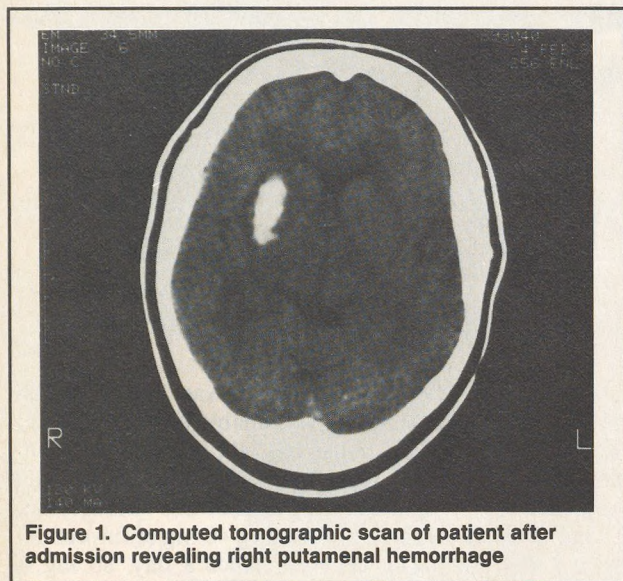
Computed tomographic scan of patient after admission revealing right putamenal hemorrhage
